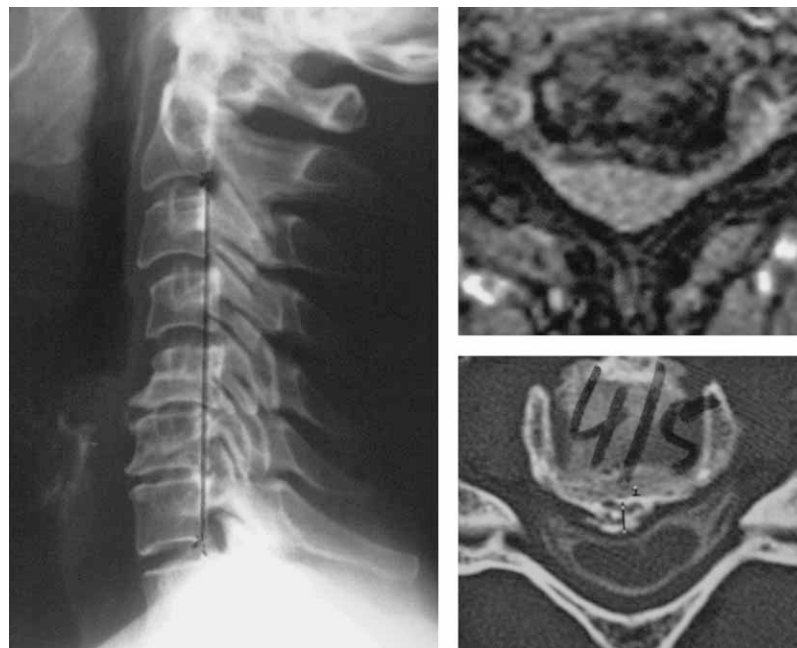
Left: Kyphotic cervical spine with negative Ishihara index. Right: Spinal cord compression shown by MRI (upper) and CT after myelography (lower).
